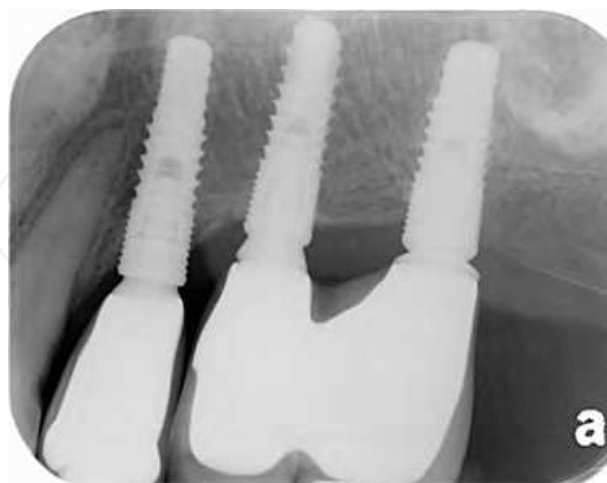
A periapical radiogram after 6 months loading.
